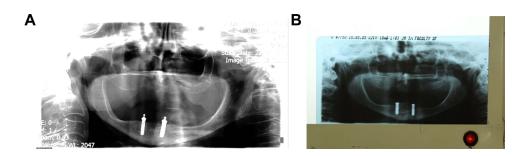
(A and B) - OPG Radiograph (A) After Healing Cap (B) After 17 Year.
